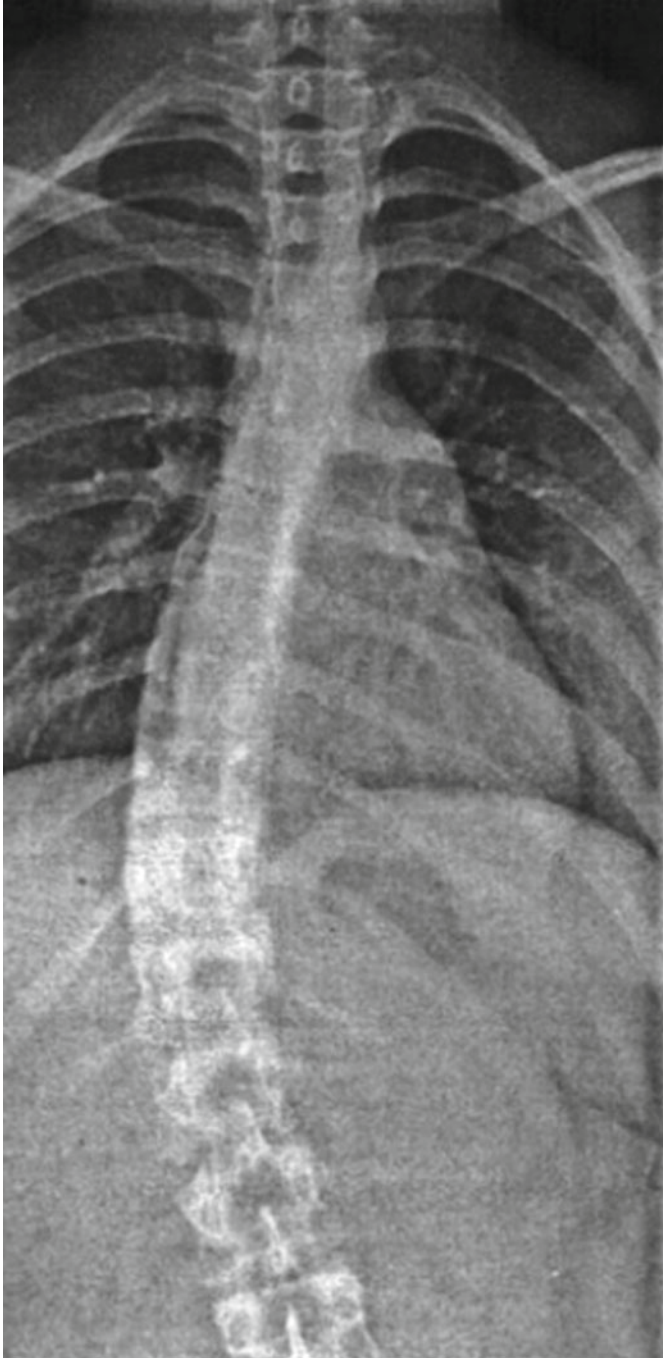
Full-length weight-bearing anteroposterior radiograph of a 15-year-old girl during school screening (Courtesy of Dushyant H. Thakkar, London, UK. Reproduced with kind permission of Springer Verlag)
